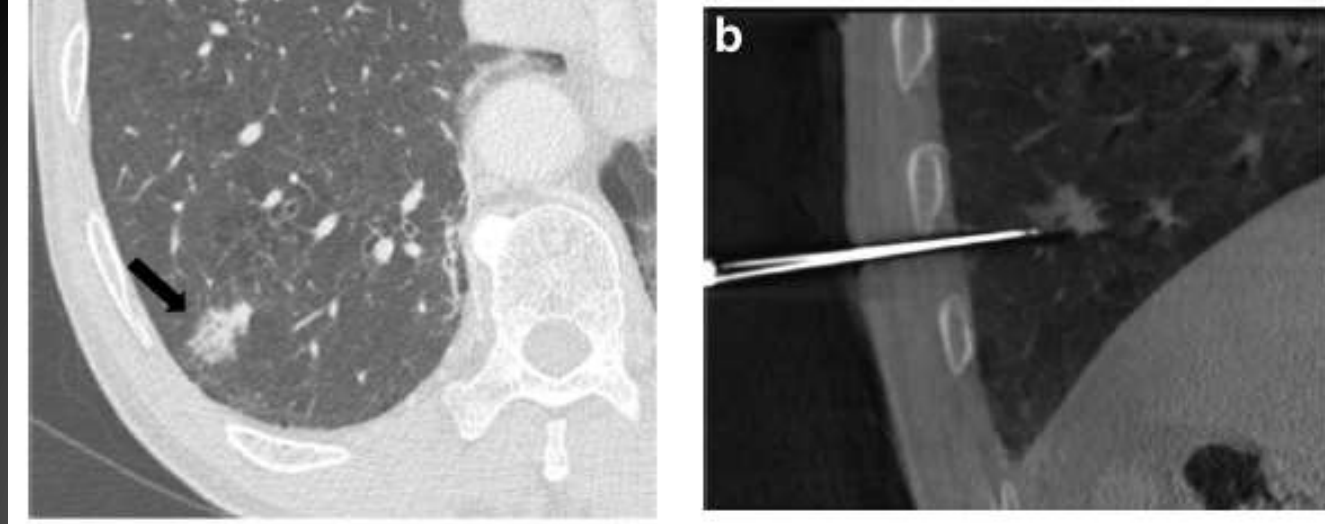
A false-negative part-solid nodule for which the biopsy result was benign non-specific pathology. (a) A diagnostic chest CT image in a 66-year-old man shows a 2.4-cm part-solid nodule (arrow) in the right lower lobe and lung cancer was highly suspected. (b) On the transverse procedural CBCT image, the coaxial needle tip abutted the mass. After the biopsy, the lesion was diagnosed as intra-alveolar macrophages and fibrins. Taking into consideration the discrepancy between the biopsy results and the CT findings, he performed a wedge resection through video-assisted thoracic surgery (VATS). Finally, the lesion was confirmed as adenocarcinoma
